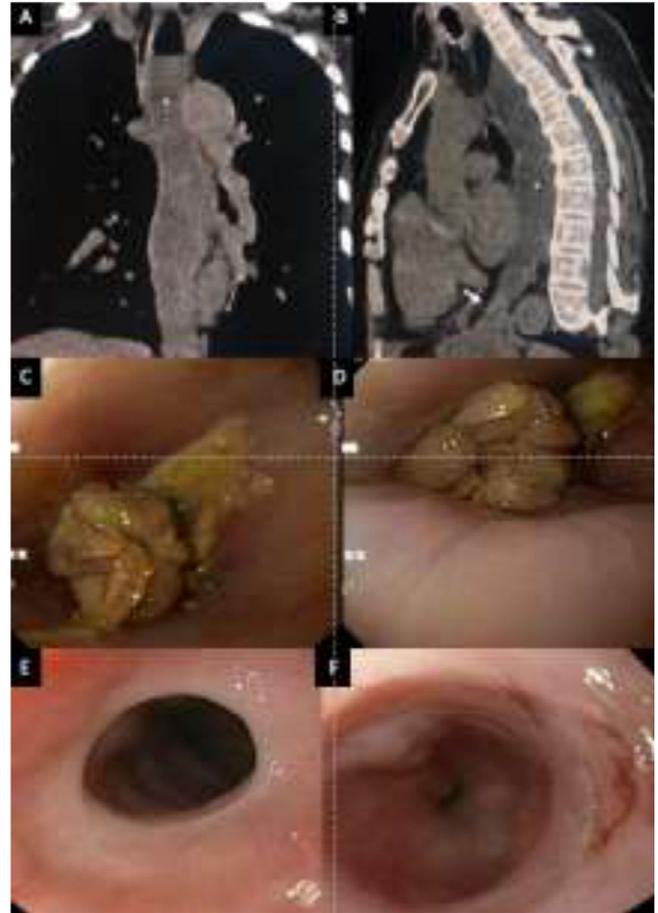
a) Chest CT (coronal) with dilation of the esophagus and an air-fluid level b) Sagittal chest CT, with stenosis in the distal third, c and d) post-ligation endoscopy with a varicose band that obstructs the esophageal lumen, edema and necrosis e) follow-up endoscopy with stenosis due to fibrosis f) post-dilation
